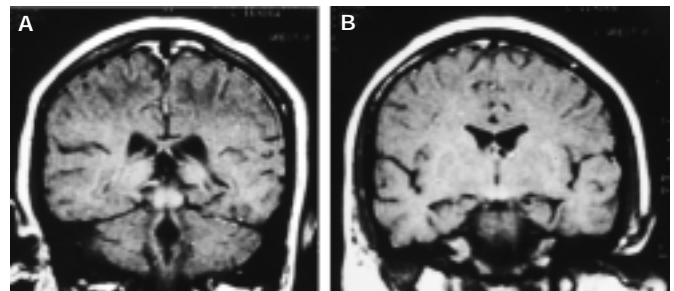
AWE. A. MRI coronal T1 gadolinium enhanced image: hyperintensities in the mesencephalic tectum, and B. in the mammillary bodies.
